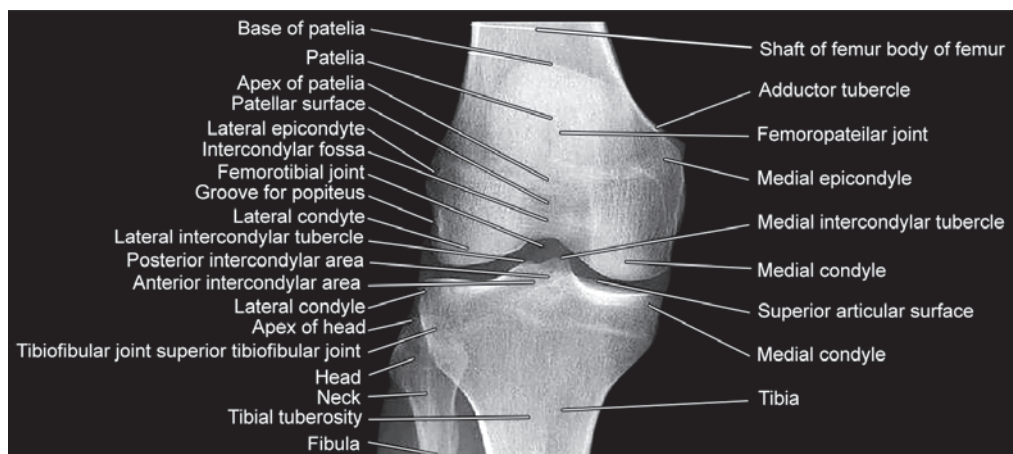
X-ray-Knee joint
